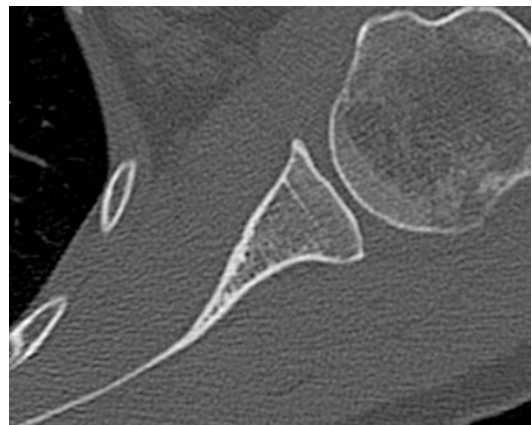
Computed tomography of a patient with posterior instability and glenoid dysplasia
